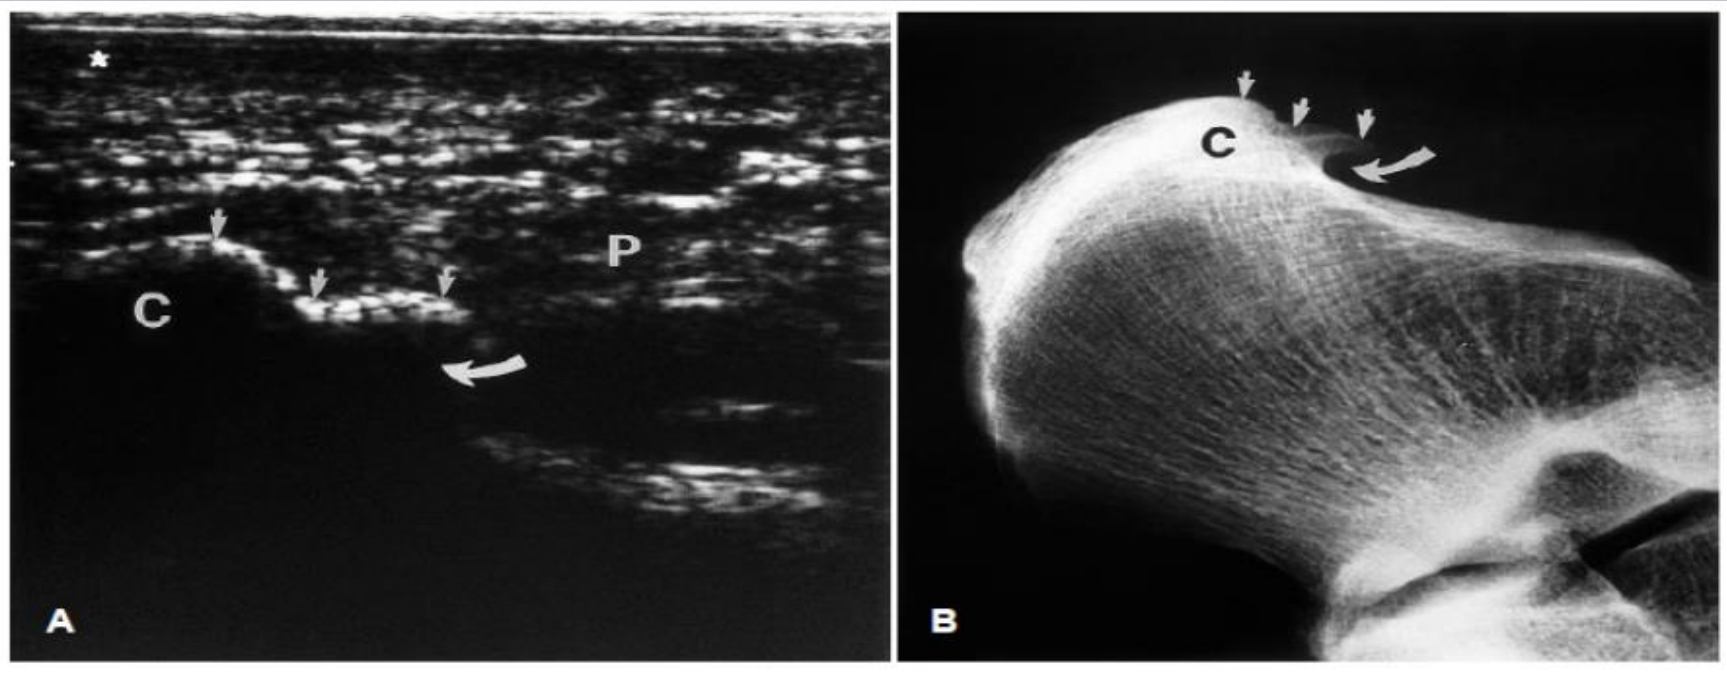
Longitudinal ultrasound of the plantar fascia with the presence of an inferior calcaneal spur. (A) A lateral view radiograph of the foot with the presence of an inferior calcaneal heel spur. (B). Source: W. W. Gibbon, G. Long, Ultrasound of the plantar aponeurosis (fascia). *Skeletal Radiol* 28, 21-26 (1999).
